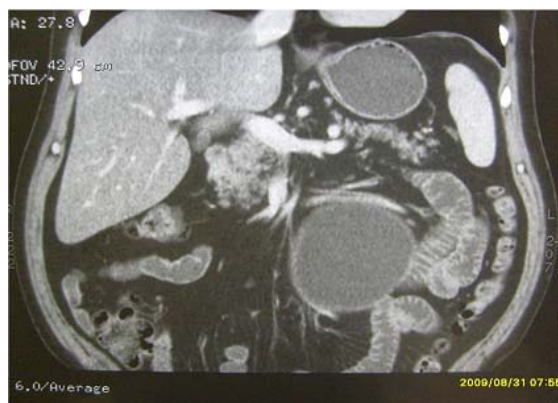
Cystic round formation in the close contact with jejunal loops on the frontal sections of multislice computed tomography abdominal scan.
